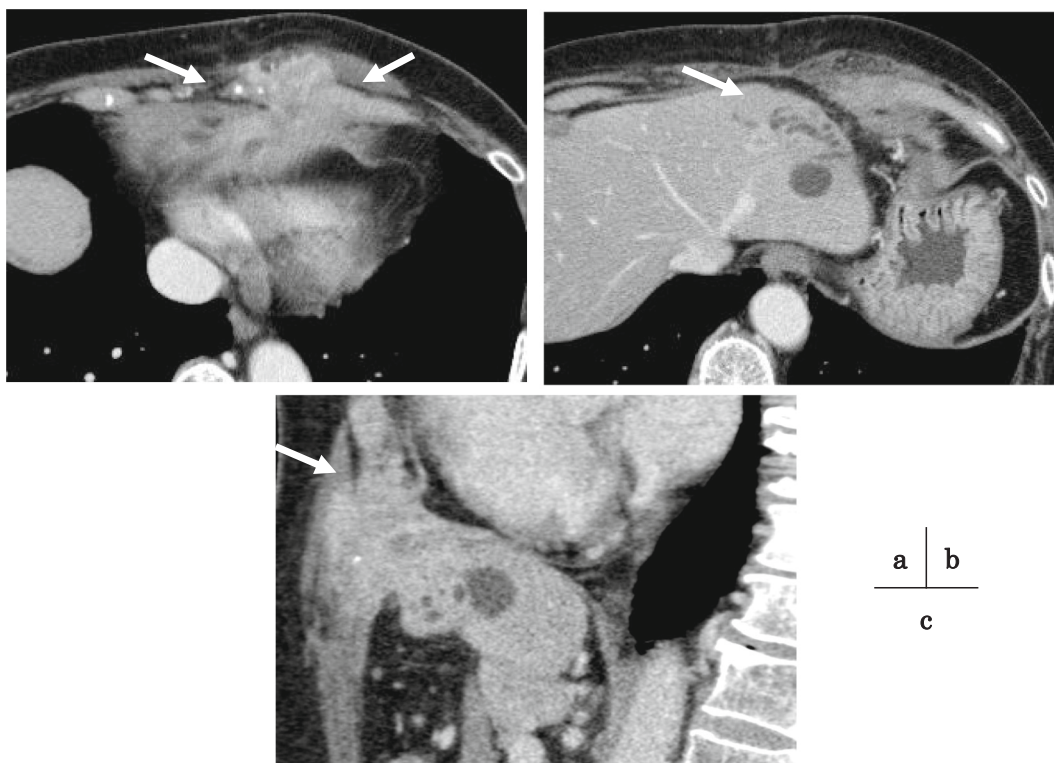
Contrast-enhanced computed tomography revealed a tumor with unclear margins in the lateral lobe of the liver, causing dilatation of the intrahepatic bile ducts in the peripheral site and invasion of the left anterior thoracoabdominal wall, diaphragm, and pericardium (a, b: axial view; c: sagittal view).
